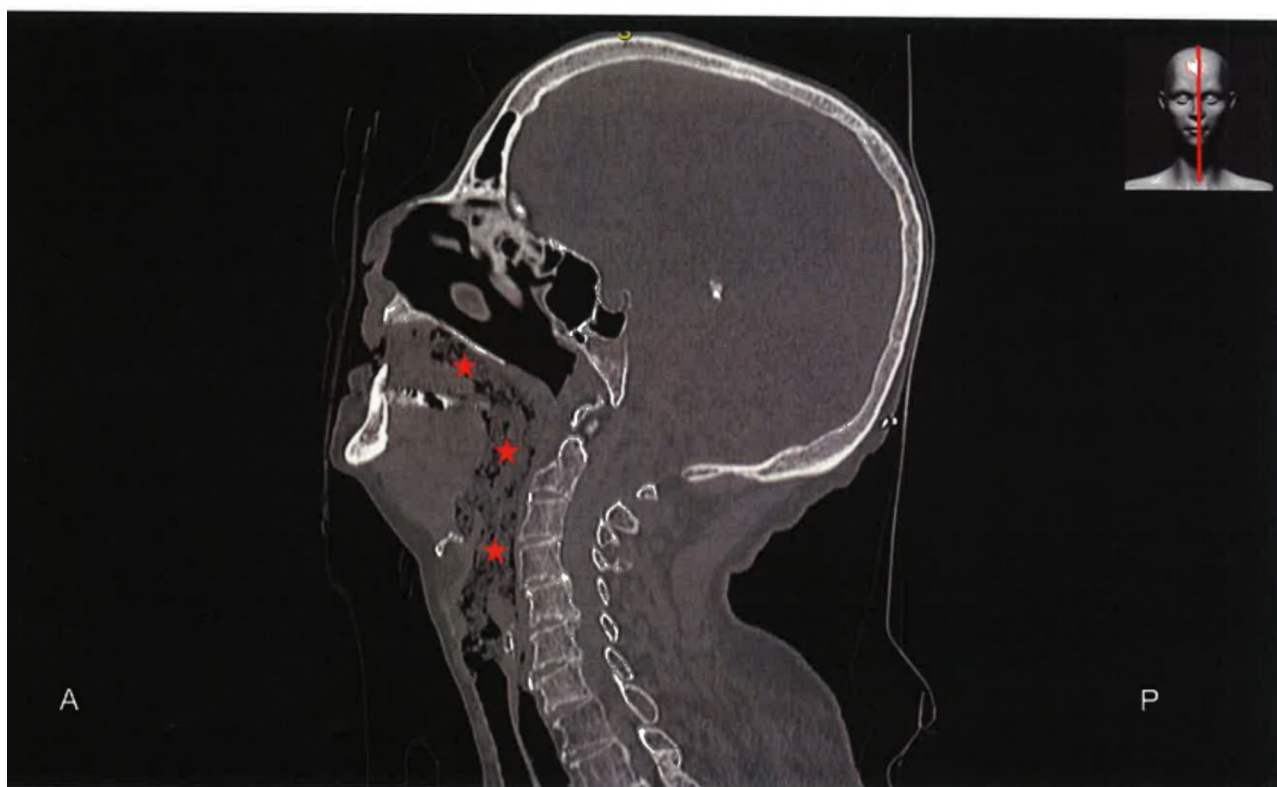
Post-mortem computed tomography (sagittal section): filling of the oral cavity, oropharynx, larynx and proximal part of the trachea with frothy material (red stars)
